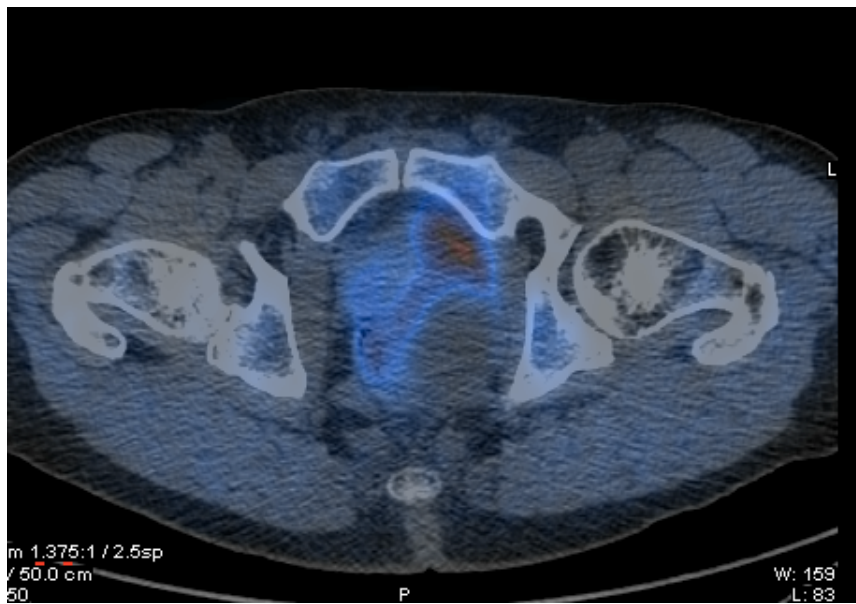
Axial fused ^{18}F Choline PET/CT showing heterogeneously avid soft tissue involving the prostate with multiple photopenic areas and soft tissue mass extending into the lateral aspect of the prostate gland.
